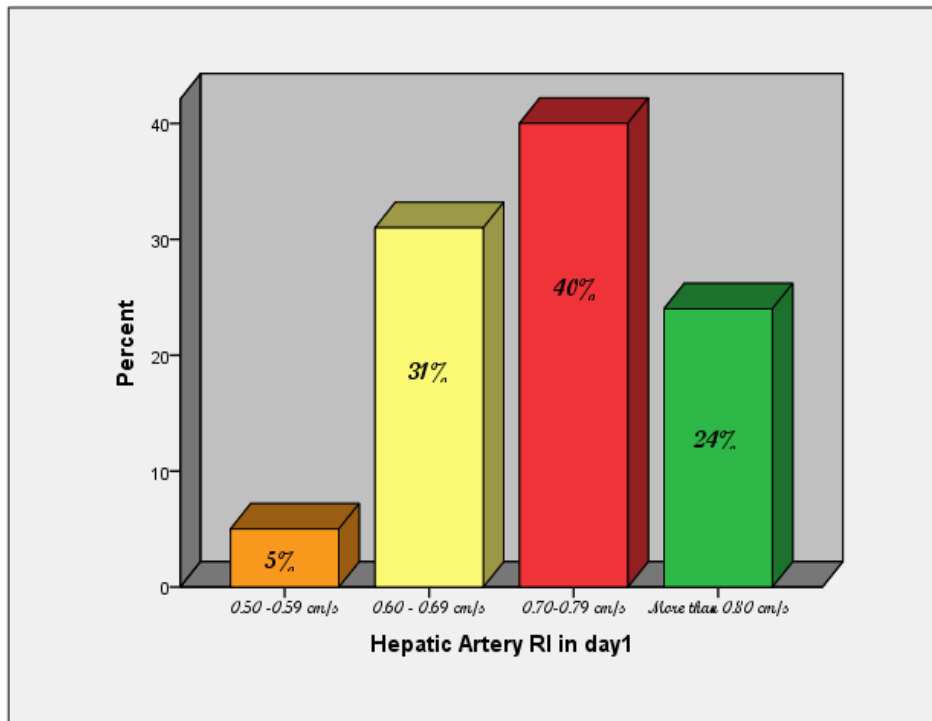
Frequency distribution of Doppler RI for hepatic artery in day1
